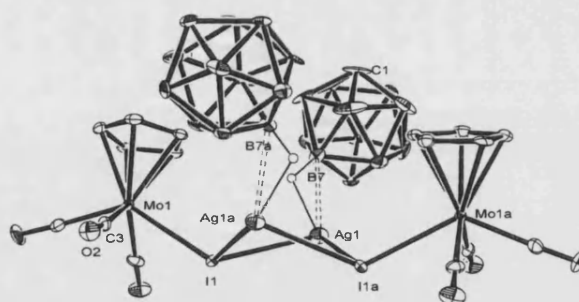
X-Ray structure of $[CpMo(CO)_3I \cdot Ag\{closo-CB_{11}H_{12}\}]_2$.⁶⁸
